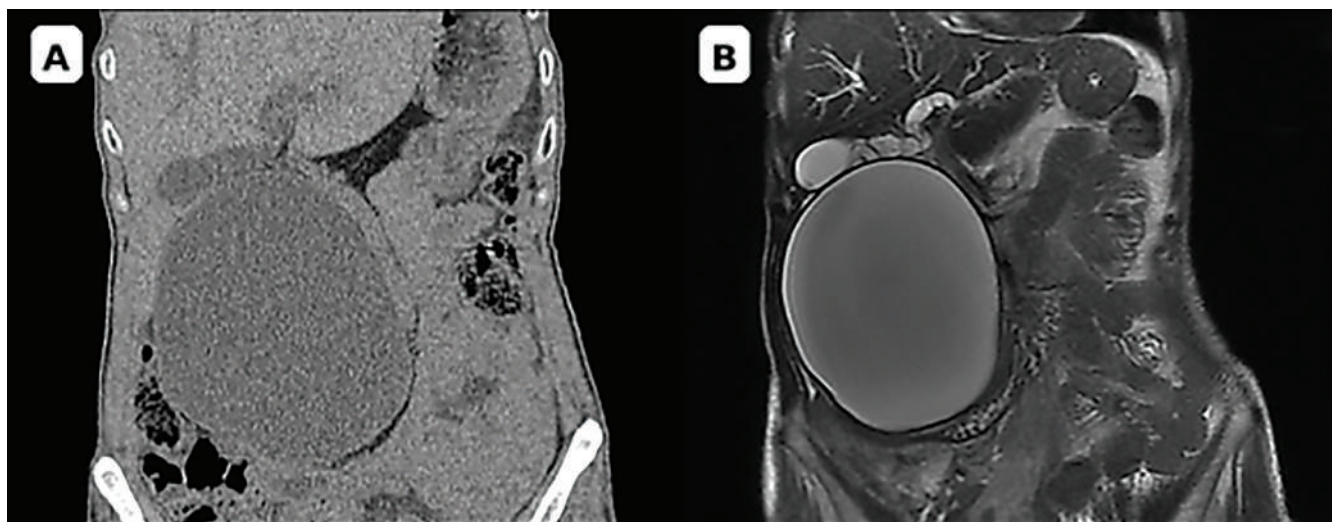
Abdominal CT (coronal view) Figure 1B: MRI, T2-Weighted (coronal view).
